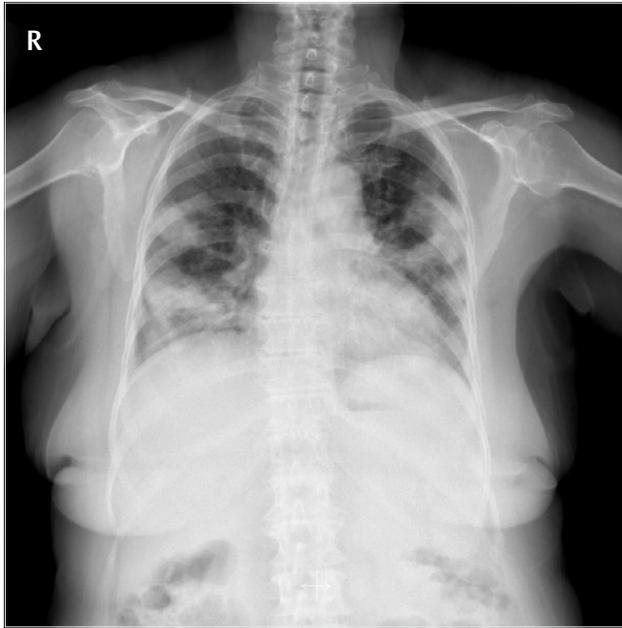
Pre-treatment posteroanterior chest radiograph
